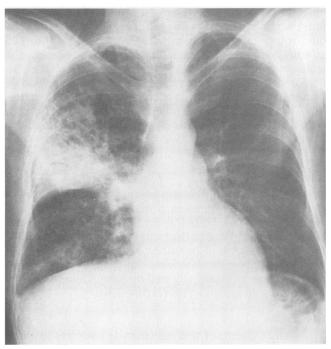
A chest radiograph taken after 10 days of therapy shows progression of the infiltrate.
